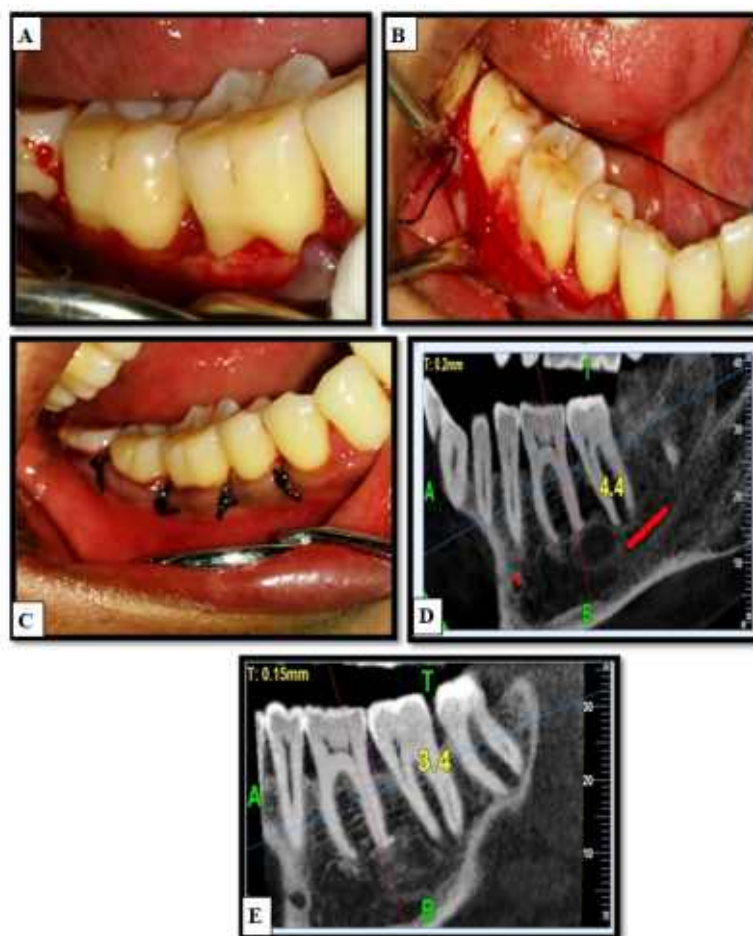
Surgical procedure (control site) A. Debridement of the defect B. Placement of the graft (perio-glas) at the defect C. Sutures placed D. CBCT at baseline E. CBCT at 6months
